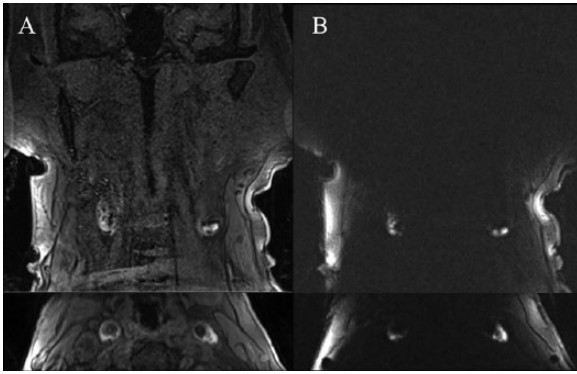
Optimized magnetic resonance imaging–intraplaque hemorrhage imaging with magnetization-prepared rapid acquisition gradient echo (MPRAGE): comparison of (A) standard Cartesian MPRAGE (top = coronal, bottom = axial reformat) with (B) an optimized stack of stars MPRAGE sequence (top = coronal, bottom = axial reformat) demonstrates complete suppression of flow artifact and background tissue signal. This patient has bilateral carotid intraplaque hemorrhage centered at the bifurcations. Both sequences were acquired in the same patient with neck-shape–specific coils.
